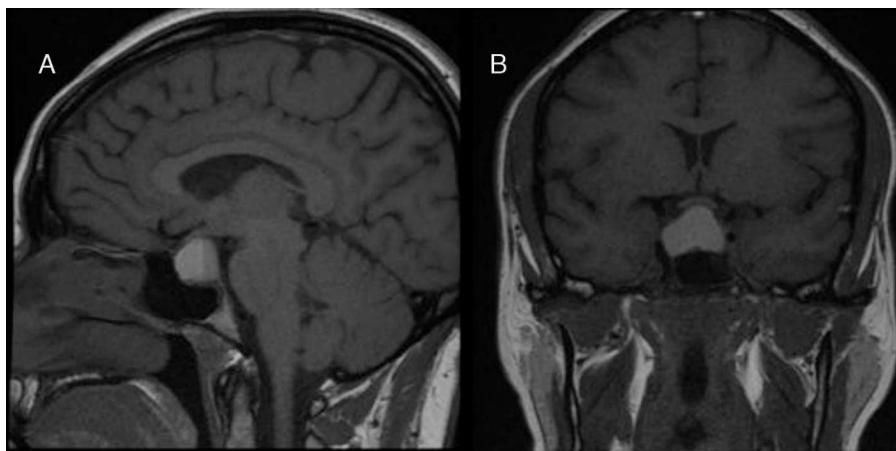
(A) T1-weighted sagittal MRI image showing a sellar lesion with suprasellar extension with a fluid-fluid level suggesting bleeding in different evolutionary stages. (B) T1-weighted coronal MRI image showing a markedly hyperintense sellar lesion with suprasellar extension related to bleeding in contact with the optic chiasm.
